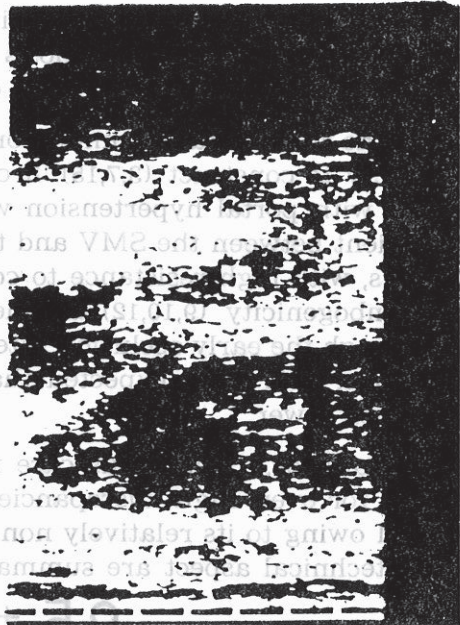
Dilatation of the IVC at the level of the shunt demonstrated by ultrasonography.
